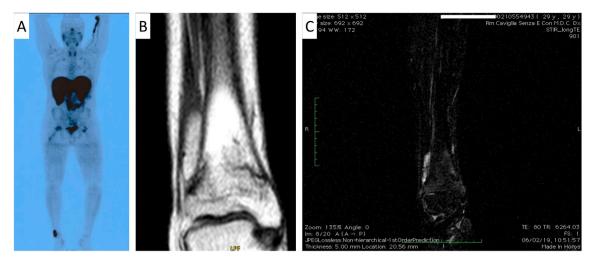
PET/CT scan showing increased uptake at tibia distal epiphysis (A). MRI imaging showing a mass at the articular surface of right tibia (B). MRI examination confirming a mass at inferior articular surface of the right tibia and the presence of lower third of tibia stress fracture (C).
